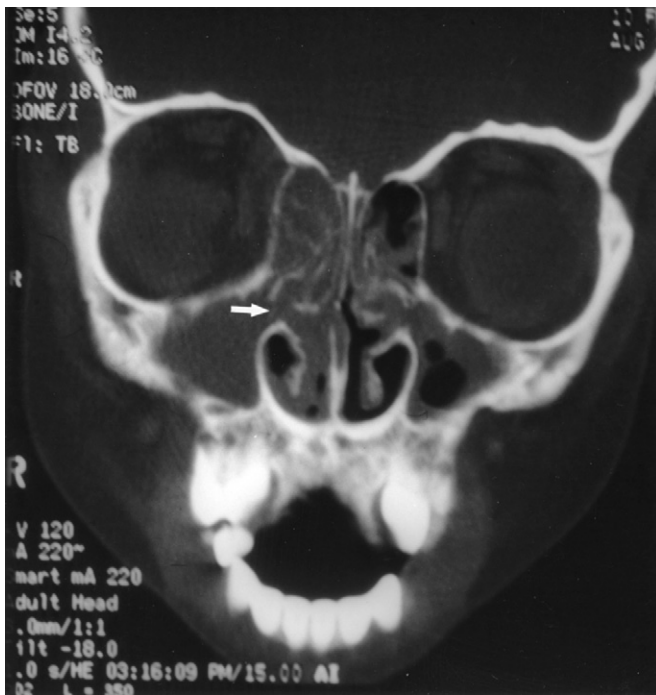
Coronal computed tomography scan showing complete opacification of the right maxillary and ethmoid sinuses with partial opacification of the left maxillary and ethmoid sinuses. Arrow indicates ostiomeatal complex.
